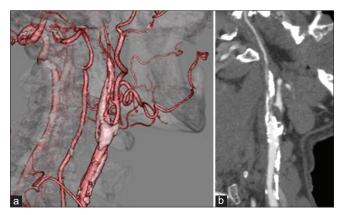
(a) Preoperative three-dimensional computed tomography angiography (CTA) and (b) sagittal CTA showing a right carotid artery with high-grade stenosis caused by a multifocal calcified plaque.
